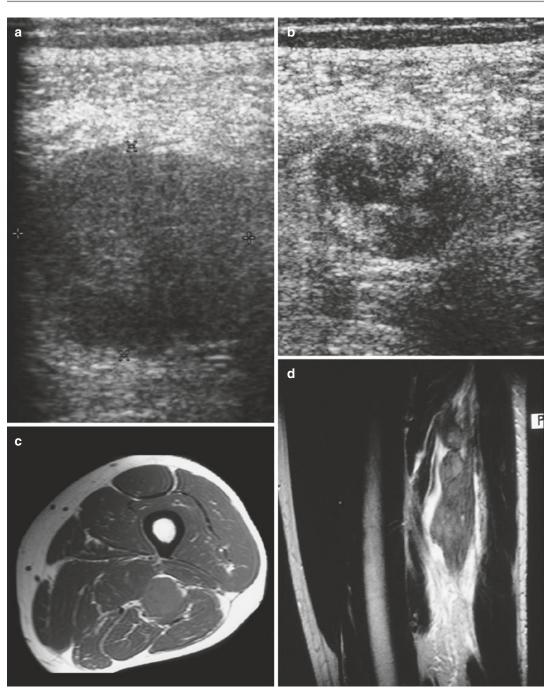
(a–d) A 66-year-old man with left sciatica presenting with a type B non-Hodgkin's lymphoma in and around the sciatic nerve: (a, b) ultrasound; (c) axial spinecho Tl-weighted MR image; (d) sagittal spin-echo T2-weighted MR image. A nodular type of lesion is found on ultrasound between the hamstring muscles. The lesion is sharply demarcated and presents with similar but more heterogeneous echogenicity to that of the hamstring muscles (a). In the caudal border of the lesion, hyper-echogenicity is due to infiltration of the tumor in the surrounding fat (b). On T1-weighted images, there is a nodular lesion in the center of the hamstrings along the neurovascular bundle. The lesion has a mildly hyperintense to isointense appearance, making differentiation with adjacent muscle groups relatively difficult (c). On T2-weighted images, a mildly hyperintense, bead-like lesion extending along the nerve root with irregular fat planes toward the biceps femoris (caput longum) muscle is seen
